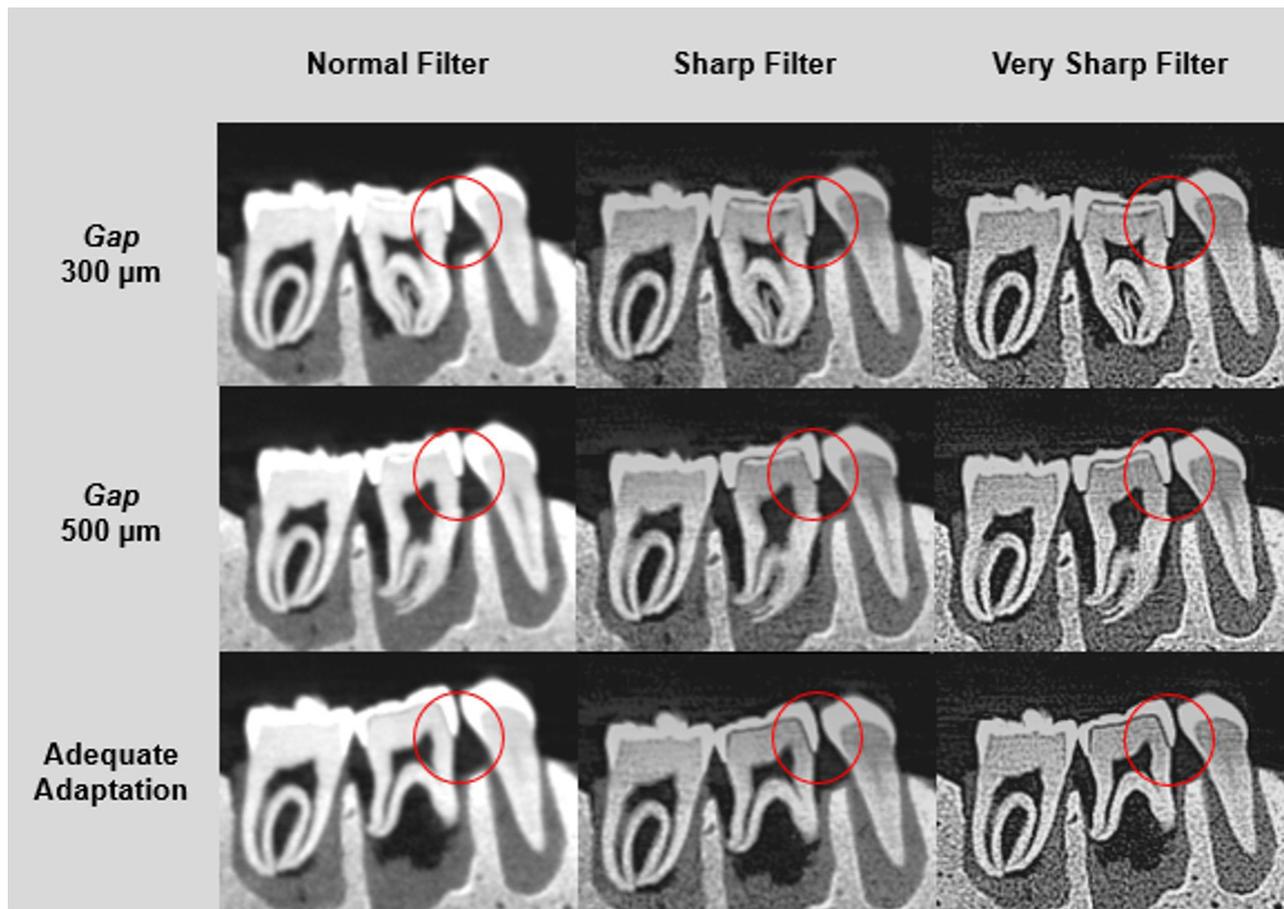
Examples of CBCT images of teeth with adapted and maladapted prosthetic crowns subjected to post-processing filters.
